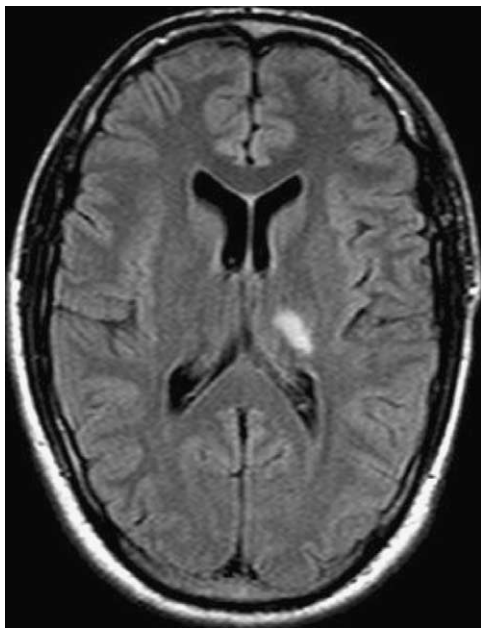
Magnetic resonance imaging scan of a left-sided postero-lateral thalamic lesion in a patient with hemihypesthesia (pat. no. 8).
